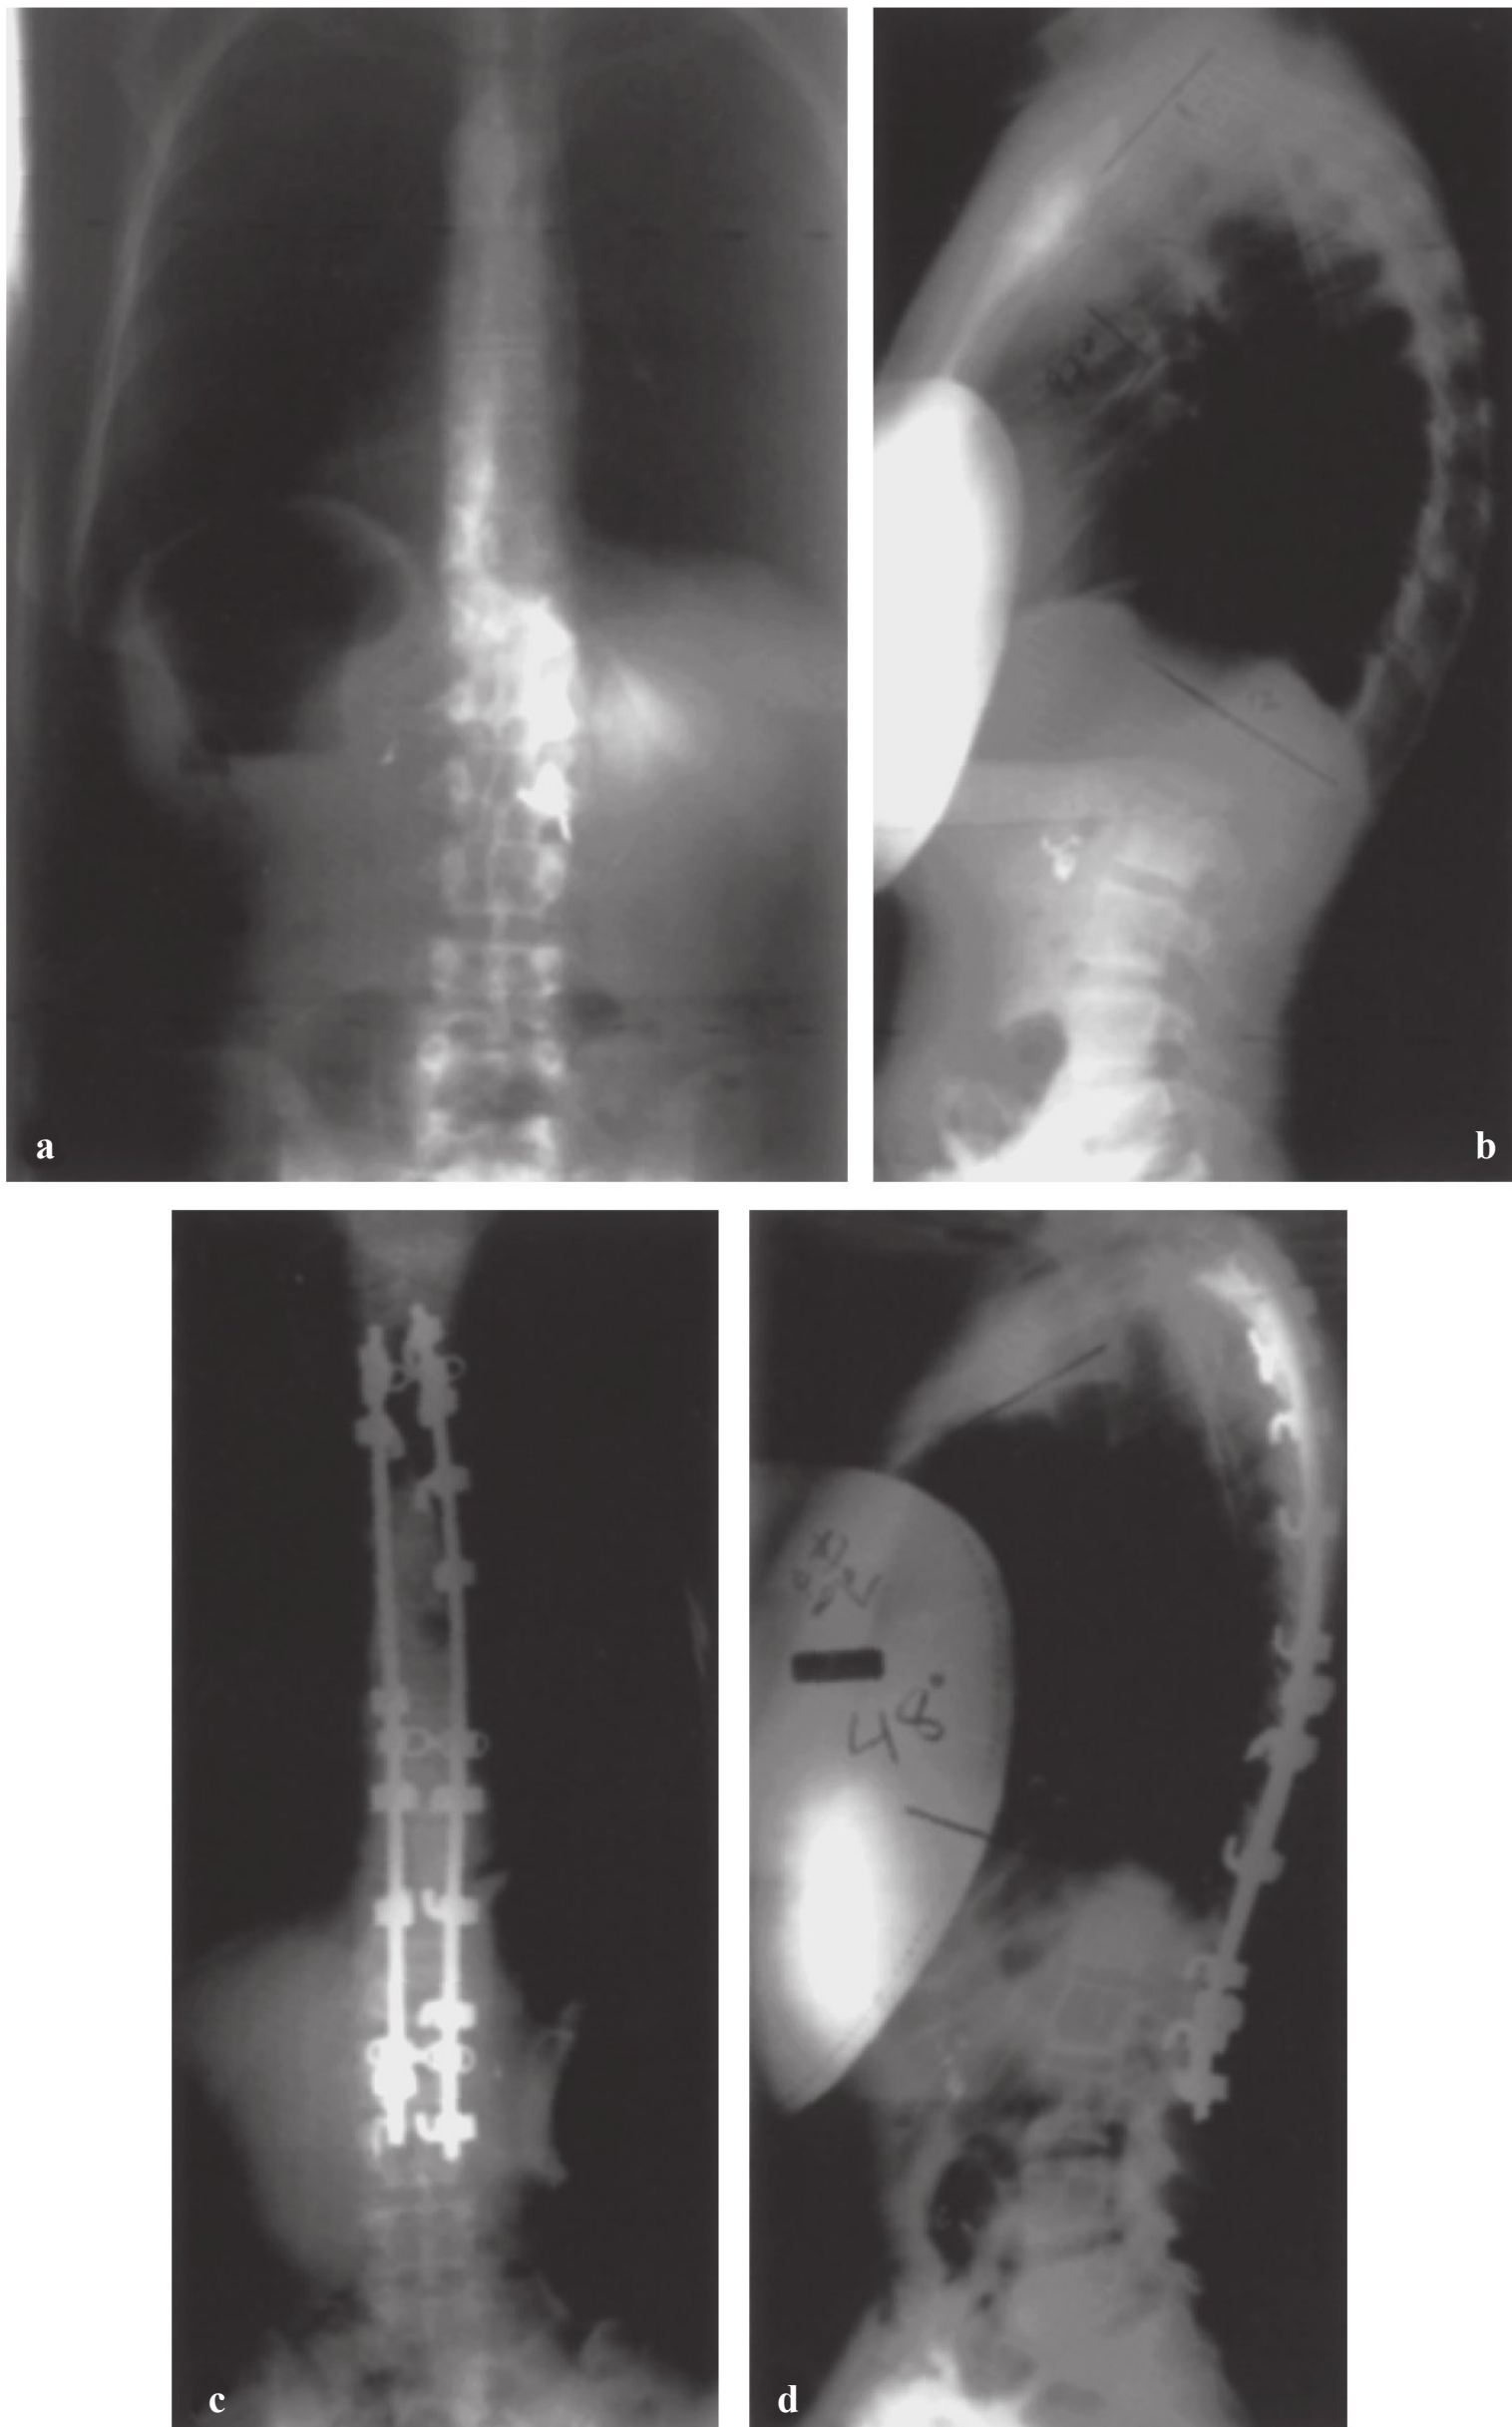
Preoperative radiographs of an 18-year-old woman with Scheuermann's kyphosis. (a) Anteroposterior radiograph demonstrating no coronal plane deformities. (b) Lateral radiograph measuring 80° of kyphosis from T1 to T12. (c,d) Because of the patient's relative flexibility, an all posterior approach was performed, restoring her sagittal balance.
